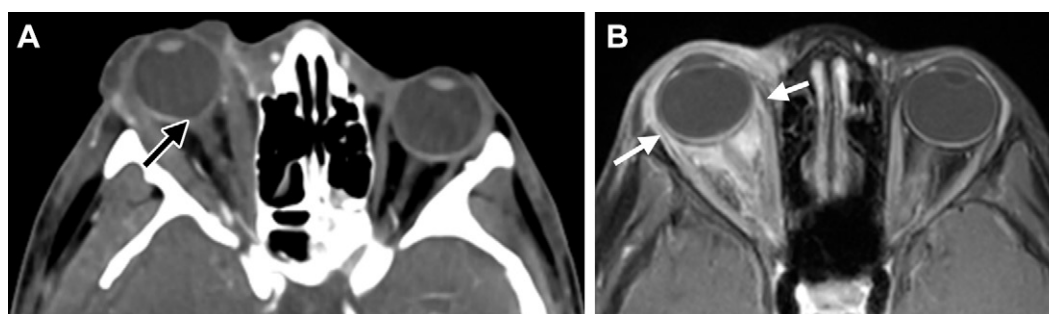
Proptosis in two pediatric patients. (A) Axial CECT image in a 14-year-old adolescent boy with central skull base fractures shows marked proptosis, stretching of the optic nerve (ON), and tenting (ie, "guitar pick" sign) (arrow) of the posterior globe. (B) Axial contrast-enhanced fat-suppressed (FS) T1-weighted (T1W) MR image in a 7-year-old girl with idiopathic orbital inflammatory syndrome shows right proptosis, bilateral intraorbital inflammatory change (greater on the right than on the left), and enhancing extraocular muscles (including the myotendinous junctions [arrows]).
